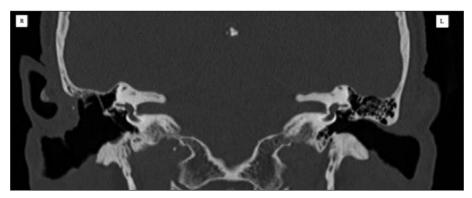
Postoperative CT scan in patient A, coronal view, post-canal wall down mastoidectomy showing no cholesteatoma on the right ear.
